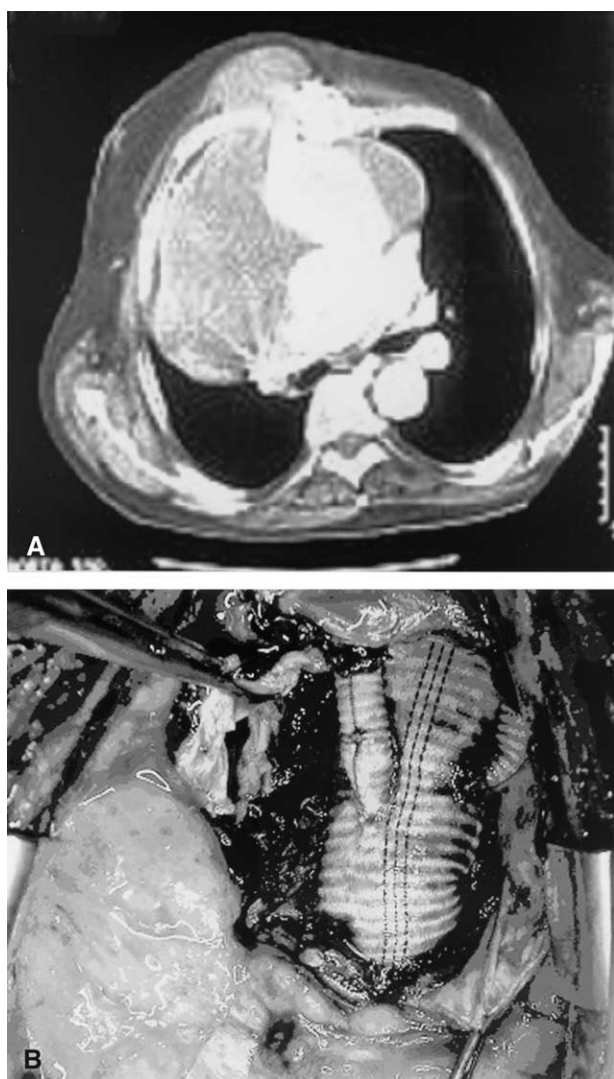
A, Angiographic CT scan showing sternal erosion and expansion of perianastomotic false aneurysm into subcutaneous tissue. B, Total replacement of ascending aorta and arch with separate brachiocephalic and left carotid artery reimplantation in same patient.
